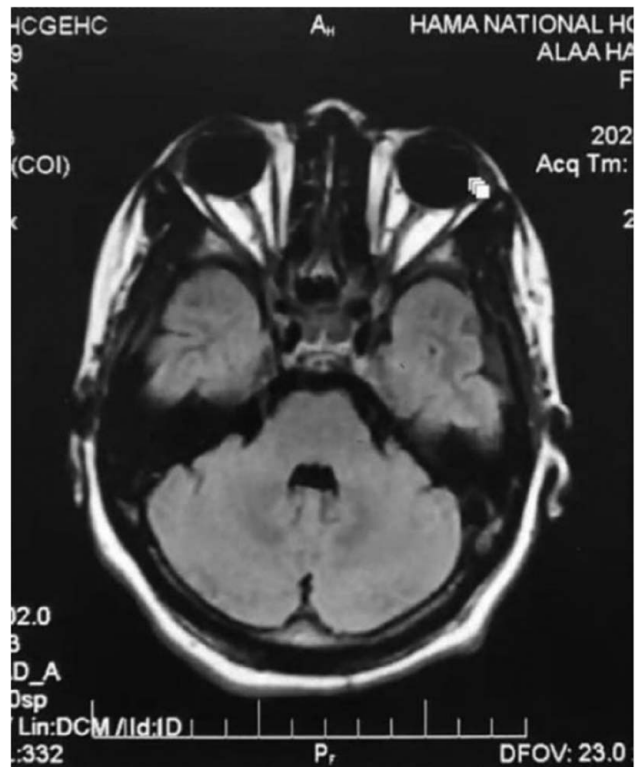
MRI study of the brain showing brainstem on cross-view.
